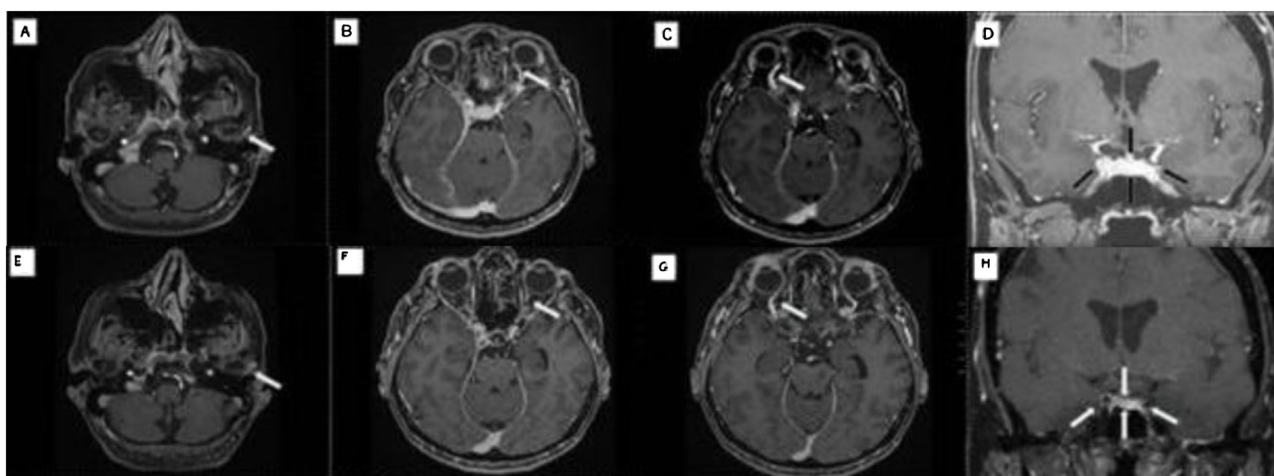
Baseline brain MRI with contrast (A, B, C, D) and follow up brain MRI after 3 months (E, F, G, H).
